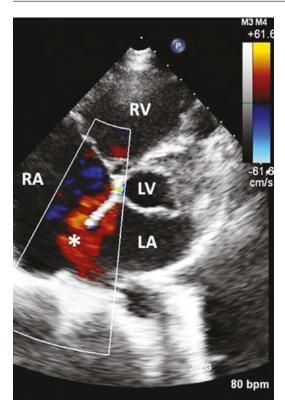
Modified apical 4 chamber view from TTE. Color Doppler demonstrates the left to right flow though a large secundum ASD
